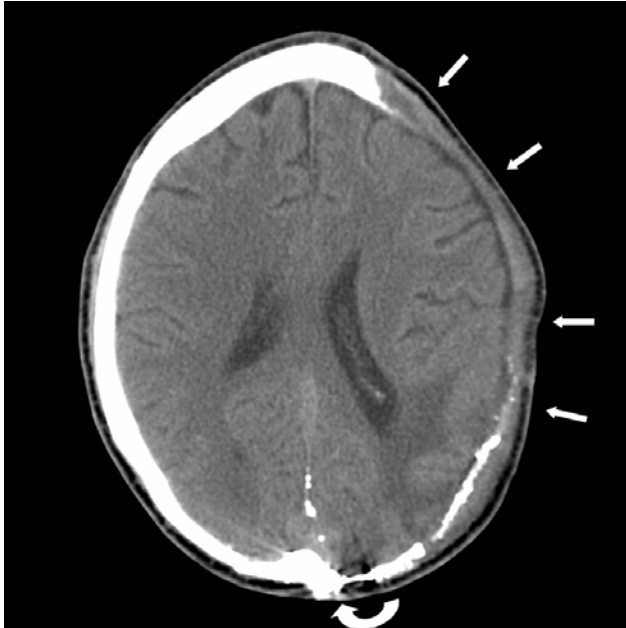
Axial head CT demonstrates the craniectomy site (arrows). Encephalomalacic changes are noted in the left parieto-occipital lobes. Beam hardening artifact is noted from metallic shrapnel (curved arrow).
